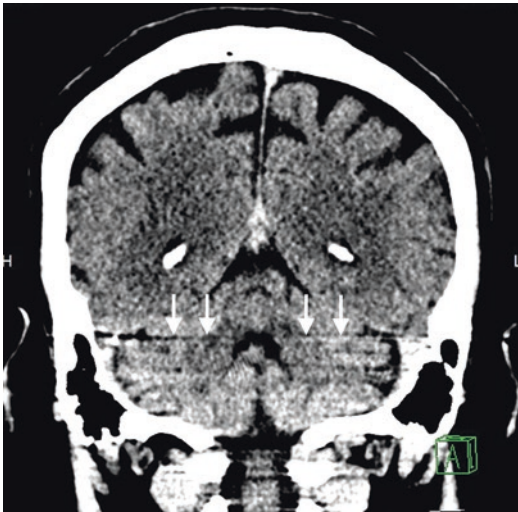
Beam hardening artifacts. Coronal CT image shows beam hardening artifacts across the cerebellum (arrows), caused by dense petrous bone at the skull base
